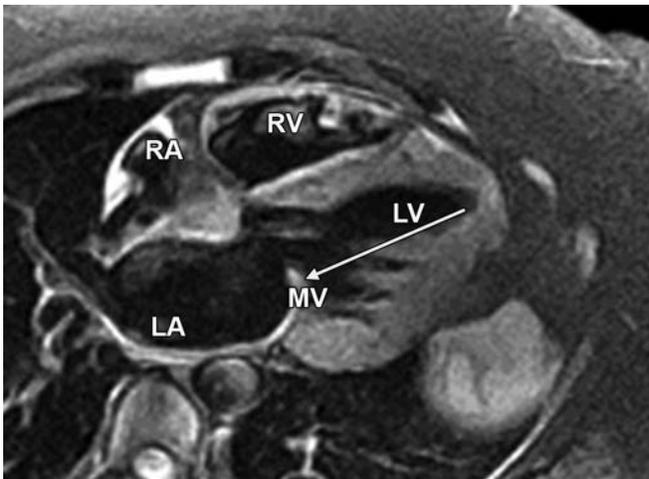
T2-weighted 4-chamber image showing increase signal (arrow) of the mitral valve mass indicating inflammation.
